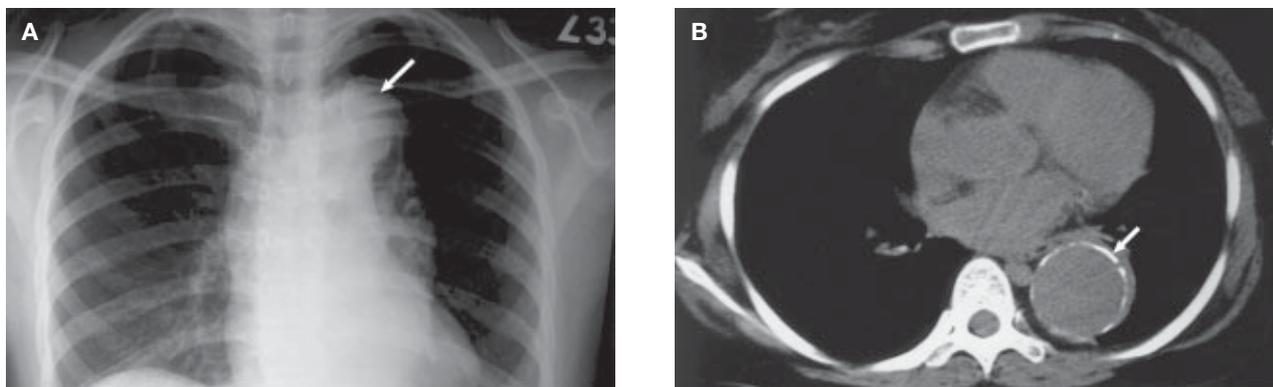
A) Posteroanterior view of the chest X-ray film shows tortuous descending aorta (arrow). B) Computed tomography scan showing the aortic aneurysm in the descending aorta (arrow).
